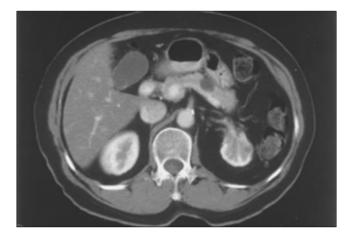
CT image representing a cystic lesion in the pancreatic body (Non dilated pancreatic duct)
